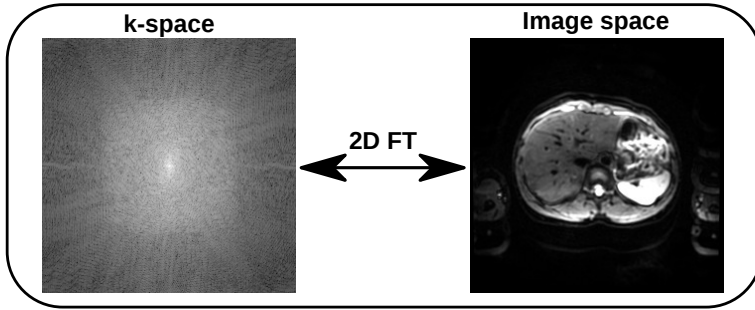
2D Fourier Transform (2D FT) of an MR image of an in-vivo liver on both k-space (left) and image space (right).
